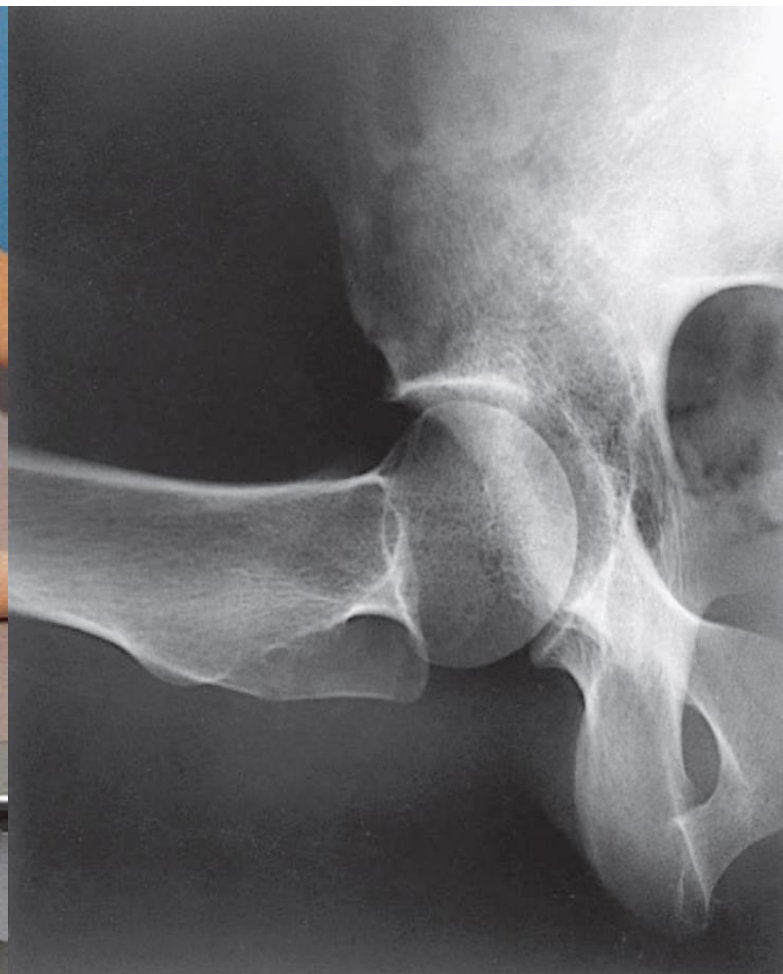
True lateral radiograph of right hip, demonstrating undisplaced subcapital femoral neck fracture.
